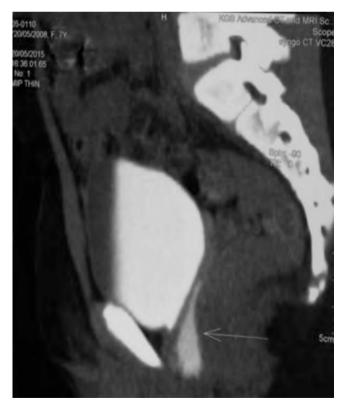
CT scan showing ectopic upper moiety ureter ending in vagina
